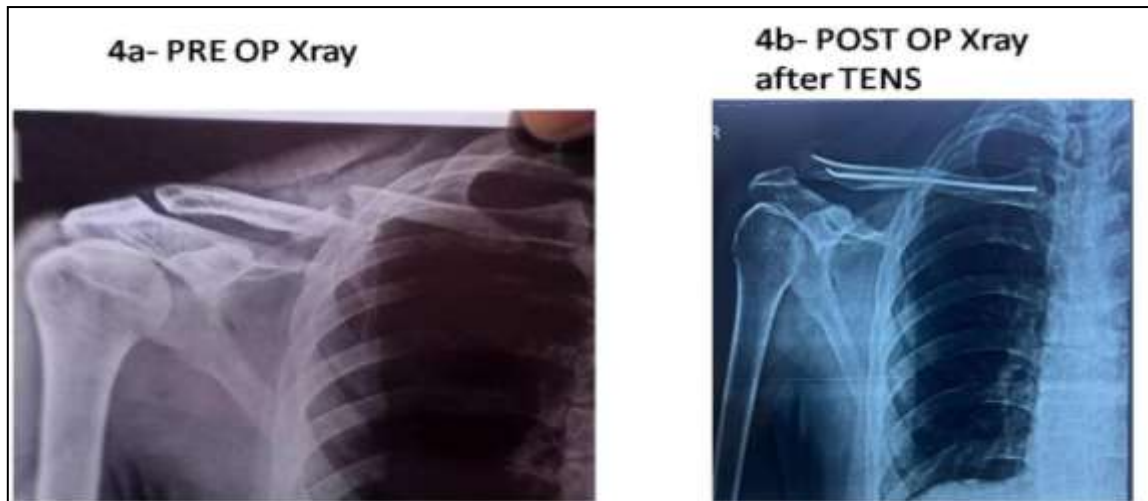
(a and b): Preoperative and post operative x-ray following TENS.
